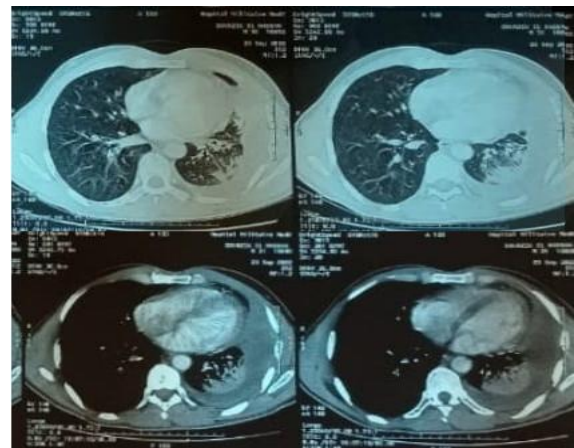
Chest CT scan showing a left basi - thoracic encysted pleurisy of homogeneous hypodense content with foci of pseudo - nodular parenchymal condensation without an air bronchogram opposite
